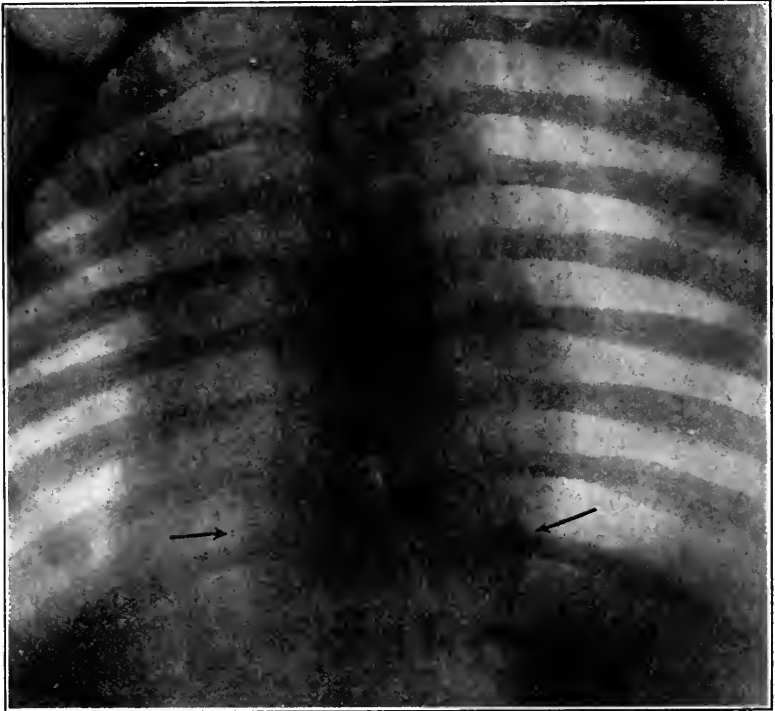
Showing large mediastinal abscess of lower dorsal region in a child aged five years. Following the insertion of a bone graft, it slowly absorbed and disappeared, as shown by frequent roentgenographic examination.
